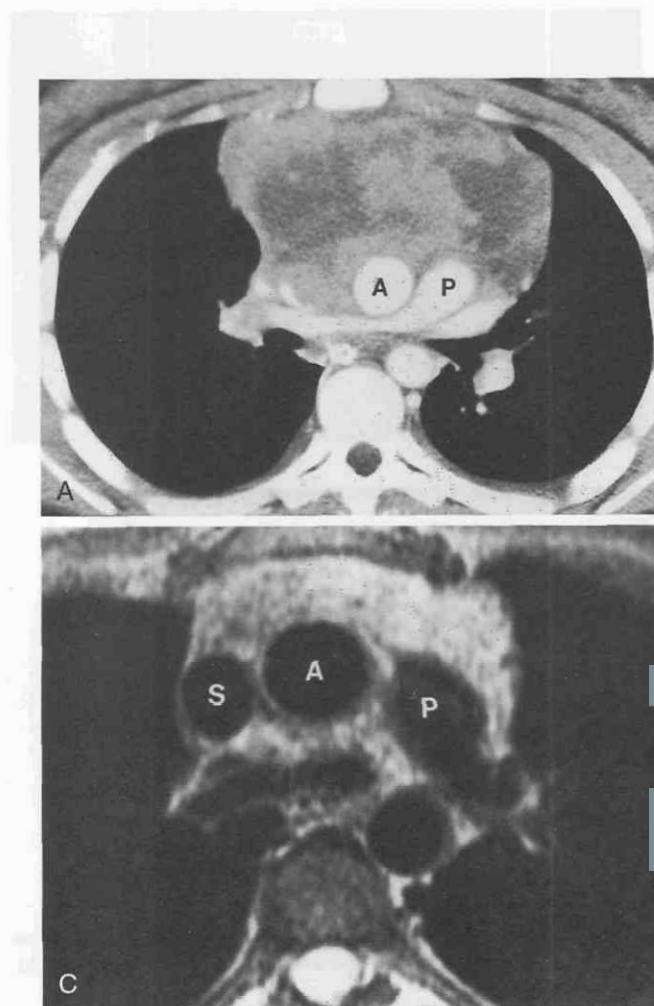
Non-Hodgkin's lymphoma. Contrast-enhanced CT (A) shows a large heterogeneous anterior mediastinal mass. T1-weighted image (B) following therapy shows an intermediate-signal-intensity mass that has decreased in size. The corresponding T2-weighted image (C) shows mass to have lower signal intensity than B. The decrease in signal intensity suggests that the residual mass is fibrotic. Biopsy confirmed fibrosis and absence of residual tumor. A, ascending aorta; P, main pulmonary artery; S, superior vena cava.
